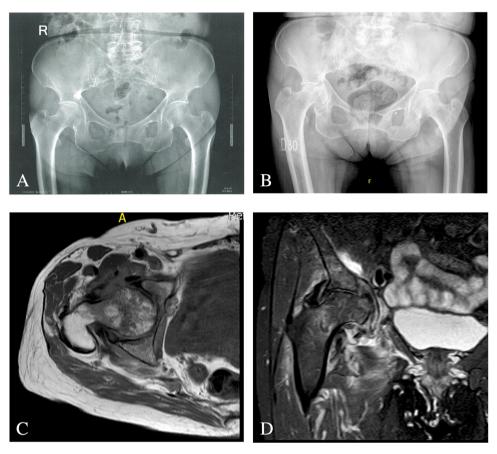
(A) X-rays of the pelvis at the onset of symptoms: mild narrowing of the joint space in both hips. (B) X-rays of the hip six weeks after the onset of symptoms: collapse of the right femoral, protrusio acetabuli and minimal proliferative changes (C) MRI T<sub>1</sub>-sequence right hip: bone marrow edema in the acetabulum, femoral head and neck and the irregular focal low-intensity bands. (D) MRI T<sub>2</sub>-sequence right hip: bone marrow edema in the acetabulum, femoral head and neck and the irregular focal high-intensity bands.
